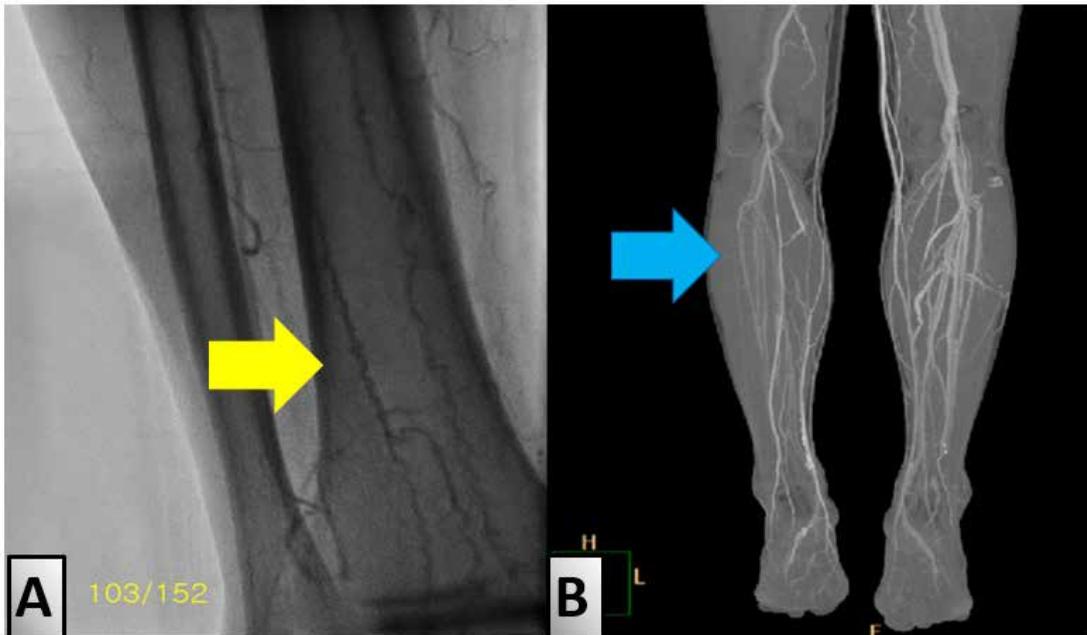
Radiologic findings. (A) Lower extremity angiography shows a 'corkscrew appearance' (yellow arrow), which is characteristic of Buerger's disease. (B) Lower extremity computed tomography shows severe stenosis in the right popliteal artery (blue arrow).
